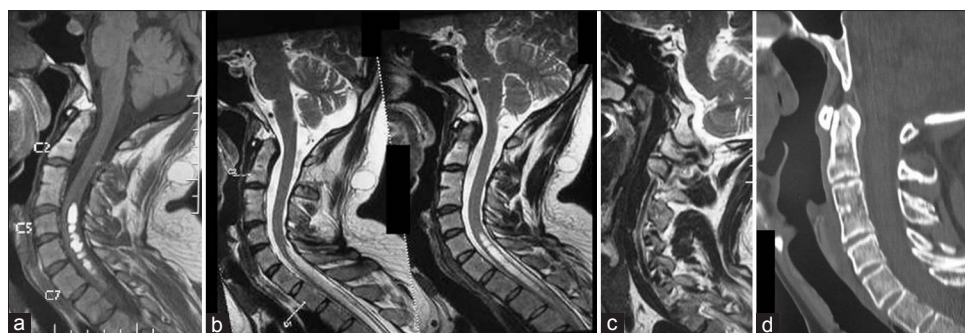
Preoperative images. (a) T1-weighted sagittal magnetic resonance imaging showing the hyperintense fat globules occupying the central canal in the cervical region. (b) T2-weighted sagittal image showing the hyperintense fat streaks in the center of the cervical spinal cord and extending caudally. (c) Sagittal cut of magnetic resonance imaging passing through the facets showing the Goel Type 2 facetal instability. (d) Computed tomography scan showing C3-4 fusion. No abnormality in the atlantodental interval is seen
